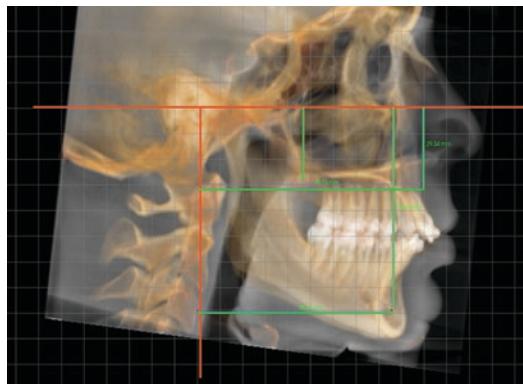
Lateral view of a CBCT scan with reference lines for various measurements
